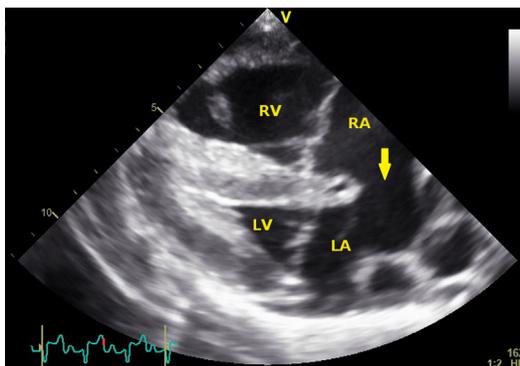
2D B-mode recording in a right parasternal long-axis, 4-chamber view focused on the atria. A large ASD is present (*arrow*), connecting the RA and the LA atrium.
